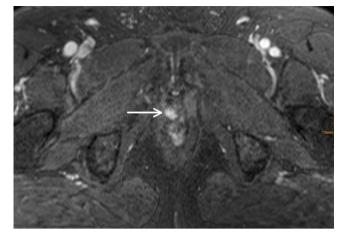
DCE-MRI of a patient with a contrast enhancing nodule (arrow) in the right prostatic fossa representing local recurrence.
